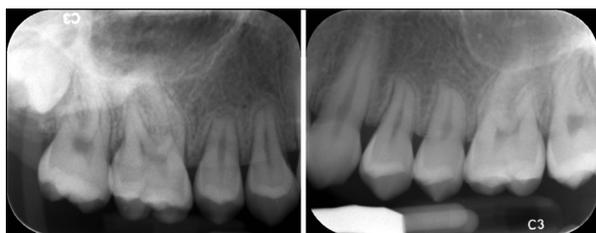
One-year postretention periapical radiographs of the upper premolar region.
